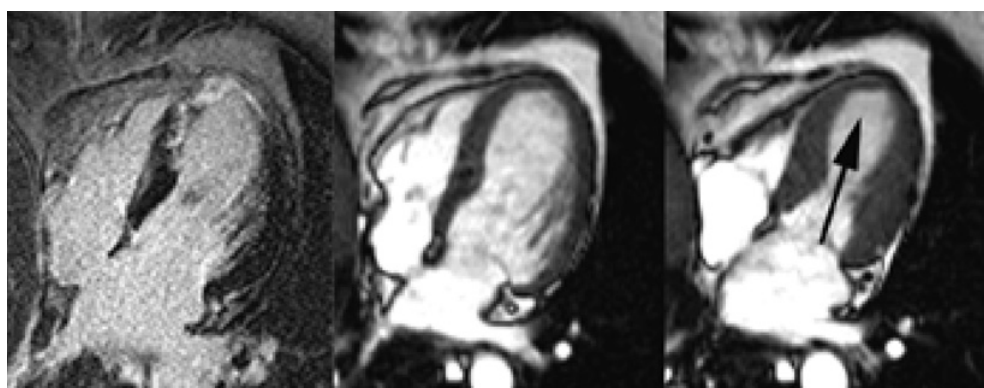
(Left) DE-MRI in acute myocardial infarction. (Middle) Cine image at end-diastole. (Right) Cine image at end-systole. DE-MRI shows transmural irreversible damage of distal septum and apex, while cine images reveal corresponding dysfunctional myocardium. (Images extracted from [Earls 2002])
